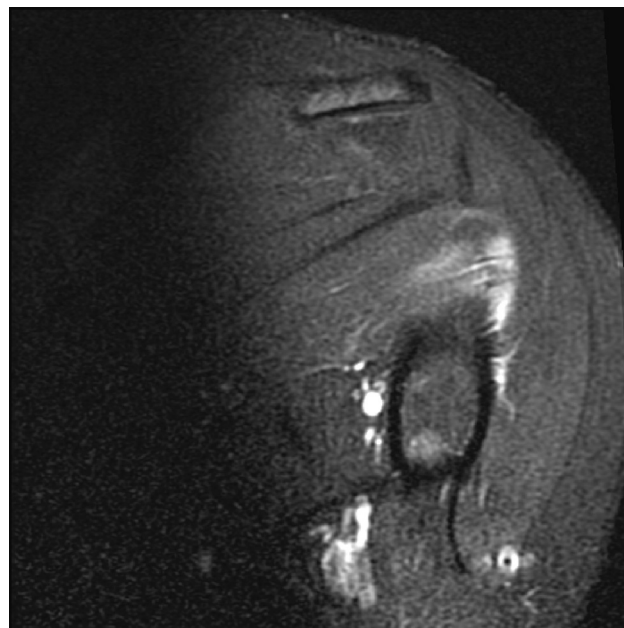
Case 1. Coronal T2-weighted fat-saturated MRI demonstrating increased signal in the distal teres minor tendon, which is consistent with tendinopathy.
